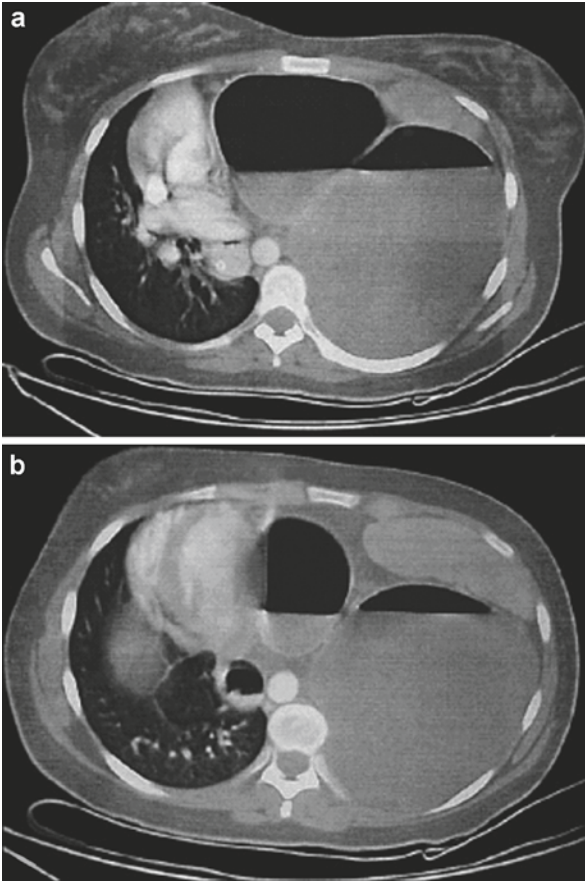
Axial CT scan through the lower thorax. (a) Air fluid level in a distended stomach with shift of the heart to the right. The “bubble” on the *right* represents the gastric antrum. Note the nasogastric tube in the distal esophagus to the right of the aorta. (b) A lower cut with the spleen visible on the *left*. The *left bubble* represents the gastric fundus. Note the “transition line” between the two bubbles representing the site of the volvulus
